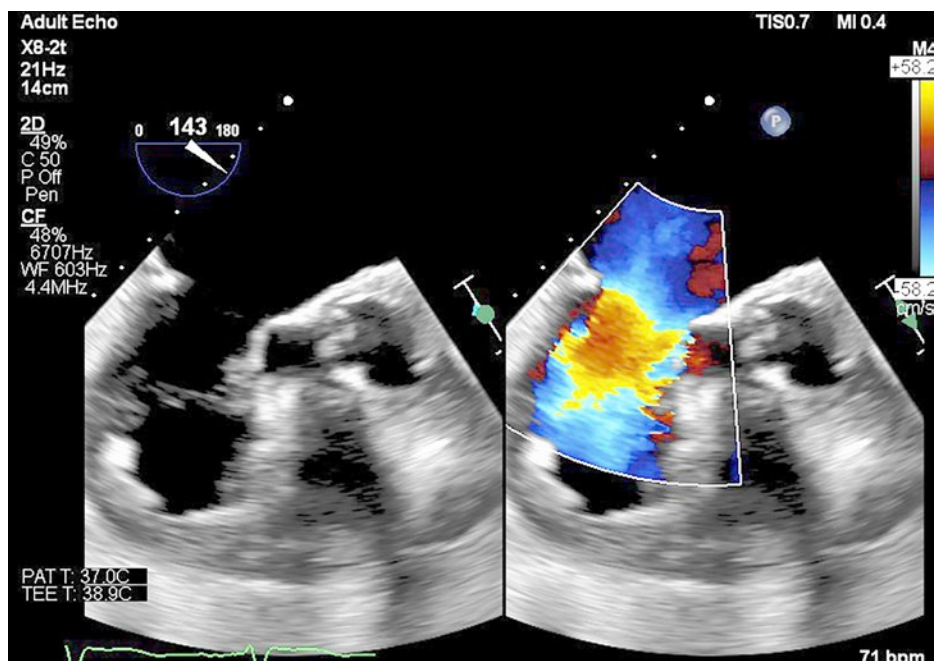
Second echocardiographic evaluation of the mitral valve showing anterior mitral leaflet elongation and hypermobility.
